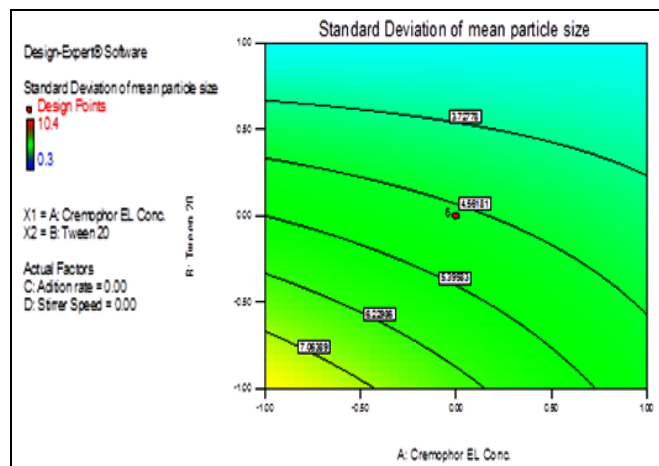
RESPONSE SURFACE GRAPH FOR STANDARD DEVIATION OF MEAN PARTICLE SIZE WITH RESPECT TO CREMOPHOR EL AND TWEEN 20 CONC. AS A PROMINENT FACTORS
